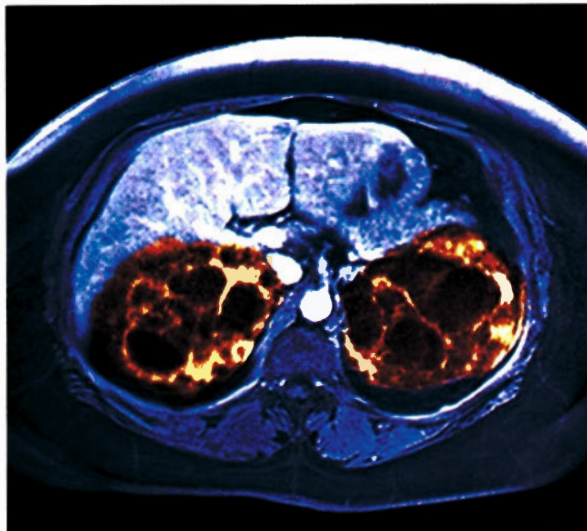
Polycystic kidneys on MRI
